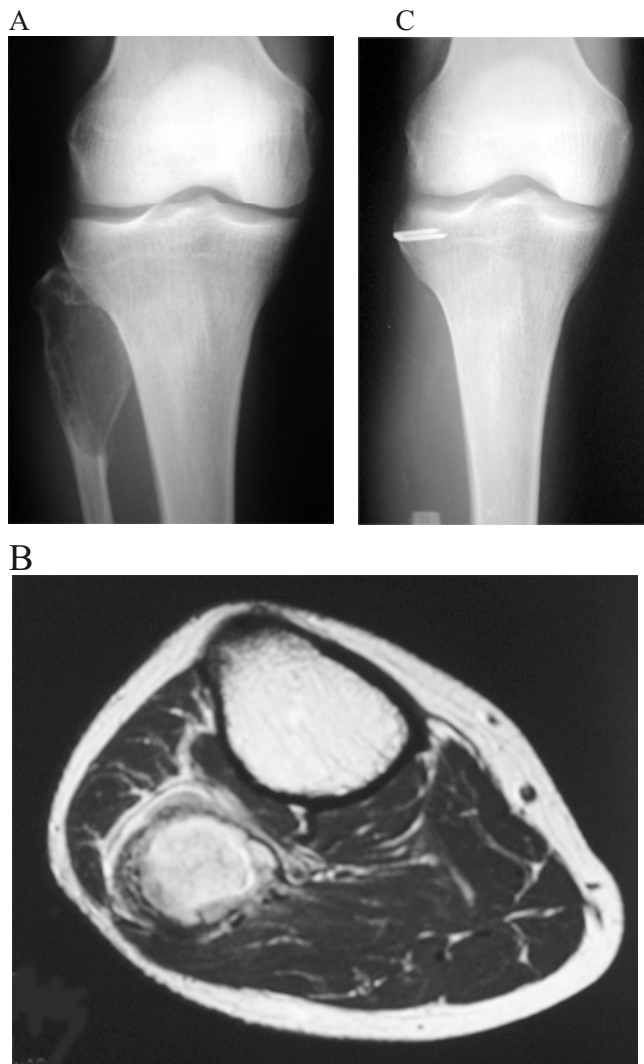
Case 1. A 56-year-old man with fibroblastic osteosarcoma of the proximal fibula. X-ray findings of the knee: A before surgery, lytic and expansile lesion in the proximal fibula; B before surgery, gadolinium-diethylenetriaminepentaacetic acid (DTPA)-enhanced T1-weighted magnetic resonance image showing high signal intensity tumor around the fibula; C at 36 months after initial surgery, the lateral collateral ligament and biceps tendon are reattached with staple. After 40 months from initial surgery, local recurrence was found. Additional wide resection was performed.
